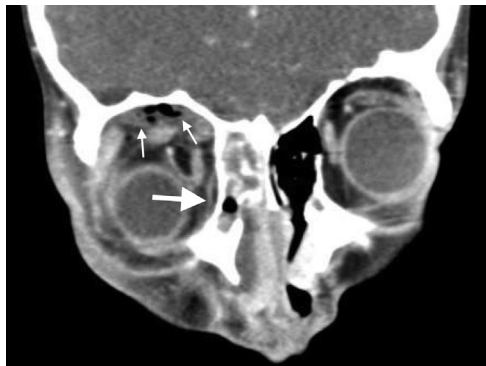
A 11-year-old male patient with a history of recurrent acute sinusitis who presented with a 2-day history of rapidly worsening nasal congestion, fever, orbital pain, and tearing. A coronal CT demonstrated a right extraconal superior orbital abscess with associated emphysema (small arrows), a small right medial subperiosteal abscess (large arrow), and adjacent ethmoid sinusitis. Upon admission, he was taken to the operating room for a superior orbitotomy to drain the superior abscess and endoscopic ethmoidectomy with maxillary antrostomy. Intraoperative cultures grew *Streptococcus anginosus* and *Eikenella corrodens*. Despite culture-directed antibiotics, his progress stalled and he returned to the operating room 5 days later for revision endoscopic sinus surgery with drainage of the right medial orbital subperiosteal abscess. He was discharged from the hospital 4 days later and returned to his normal state of health after completing outpatient intravenous antibiotic therapy.
